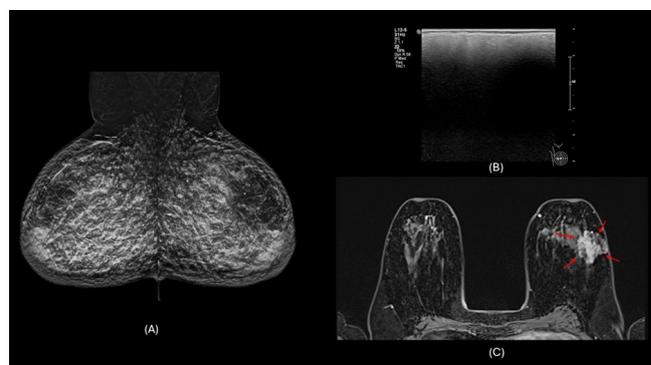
A 50-year-old woman presented for routine screening mammography and was surprised to learn that a supplementary breast MRI was required due to the obscuring effect of previously injected breast fillers. She had undergone the procedure more than a decade earlier and she had been informed at the time that the fillers were not permanent.
